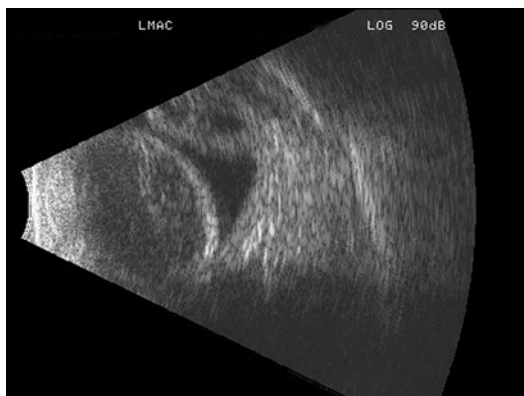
Longitudinal sonographic section through the macula. Note the nasal and temporal bullous choroidal detachments which are not quite apposed to each other
